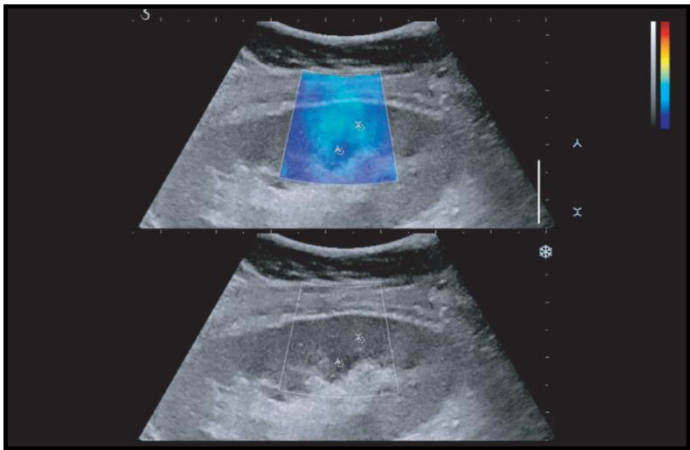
SWE of a graft kidney. The upper panel is the color-coded elasticity map scaled from 0 to 60 kPa. The lower panel is the simultaneous grayscale ultrasound image. The regions of interest are placed in the cortex (X) and the medulla (A).
